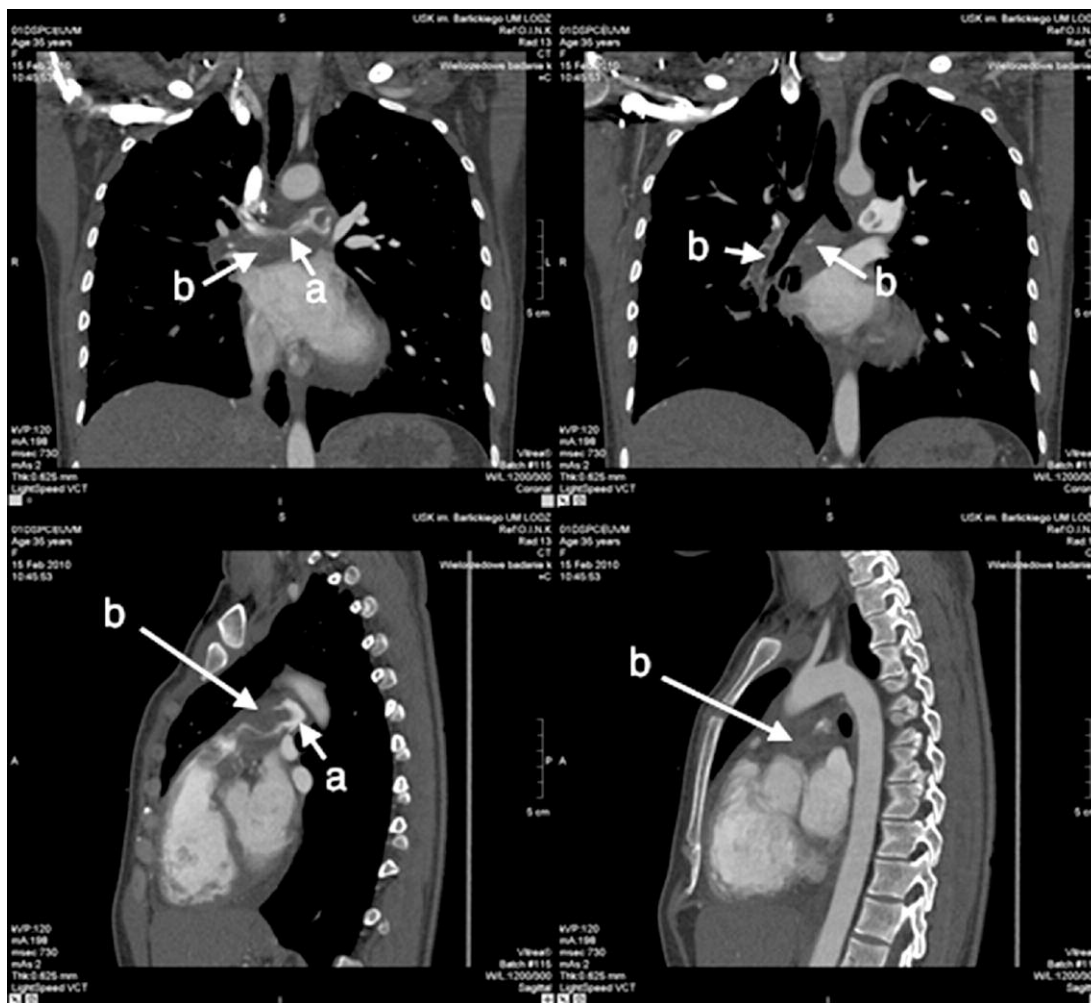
Computed tomography of the chest: (a) residual blood flow to the upper lobe of the right lung, (b) tumor – intimal sarcoma in the trunk and the right pulmonary artery
